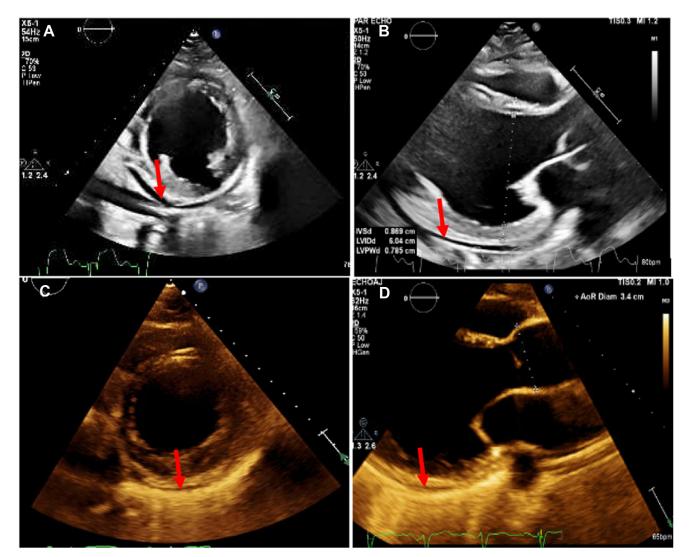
Transthoracic echocardiogram at postoperative days 21 (A, B) and 112 (C, D); parasternal short-axis (A, C) and parasternal long-axis (B, D) views show stable residual trivial pericardial effusion (*red arrow*).
